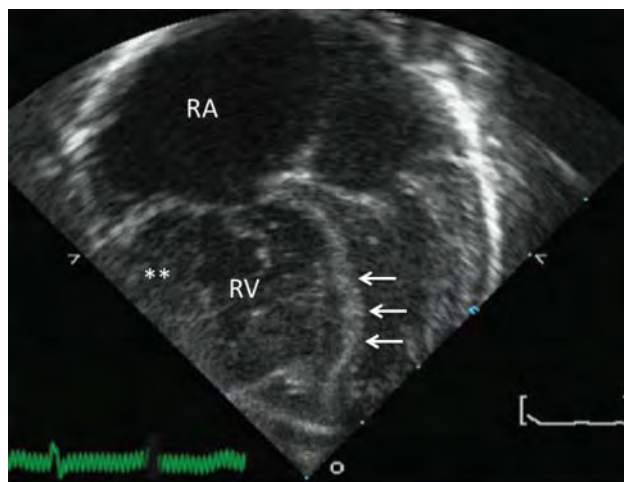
Transthoracic echocardiogram in a newborn with critical pulmonary valve stenosis. Note the dilated right atrium (RA) and the severely hypertrophied right ventricle (asterisks, RV). The bowing of the interventricular septum towards the left ventricle (white arrows) suggests a right ventricular pressure higher than the left ventricular pressure.
